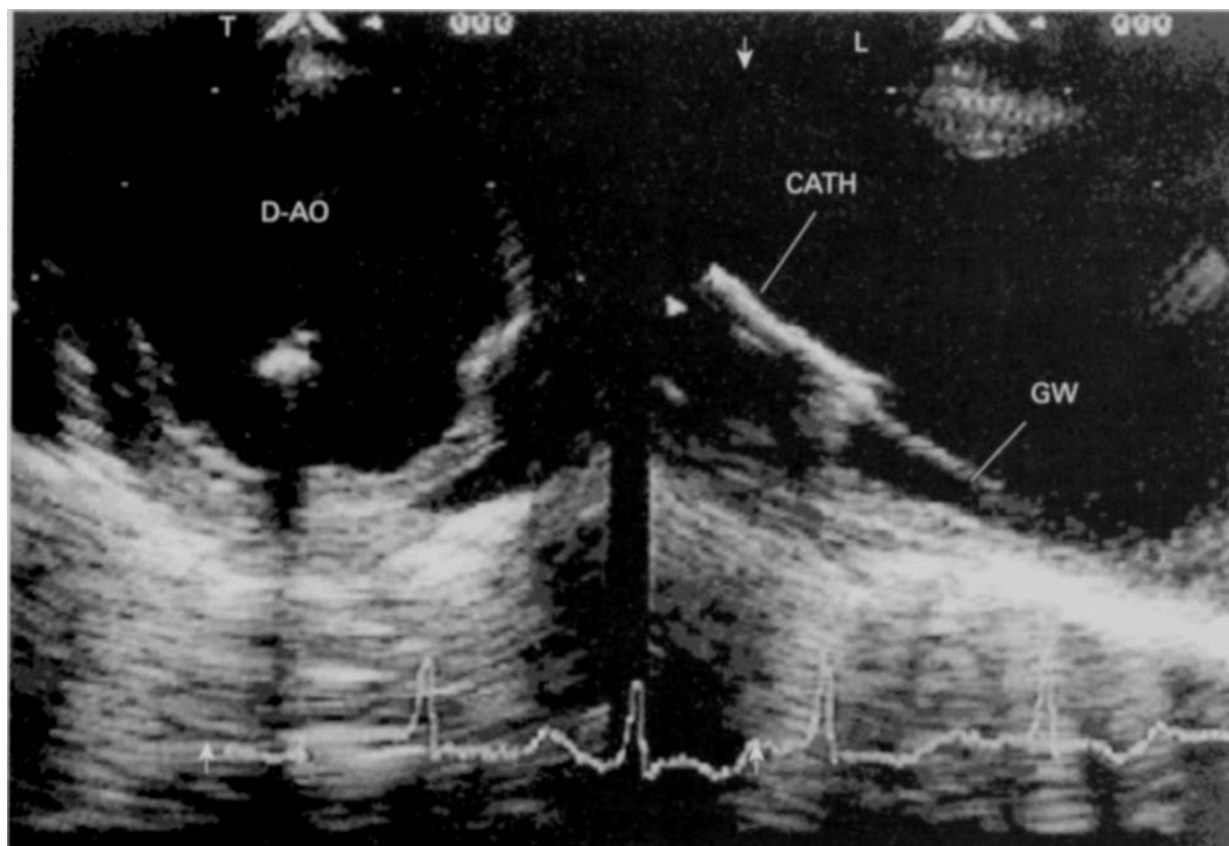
Transoesophageal echocardiogram showing placement of intra-aortic balloon pump catheter (CATH) in the descending aorta (D-AO). The catheter is being advanced along the guidewire (GW).
